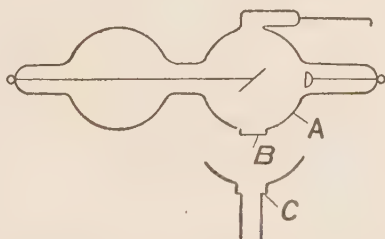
“A” represents a bulb of lead glass. “B” a window of soda glass which allows X-rays to be passed through it. “C” a lead glass shield which fits on to the projection of the main tube, thus confining the rays to an area equal to the opening at the end of “C.” This tube was designed by Dr. H. G. Piffard, and is intended to protect the operator as well as the parts of the patient it is desired not to ray.
